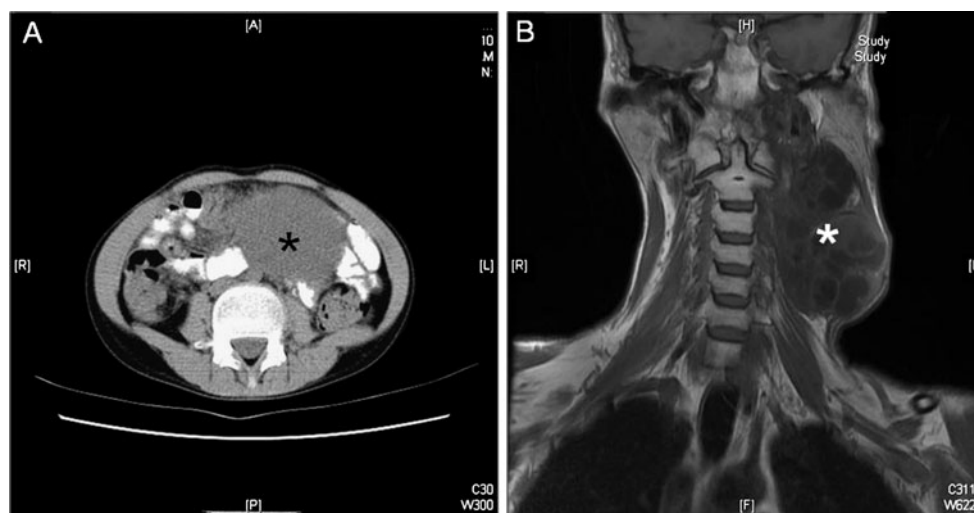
a Case 21. Computed Tomography (CT) scan of abdomen showing a large, hypodense soft tissue mass measuring $7.6 \times 11.2 \times 15$ cms, extending superiorly up to the level of the lower pole of the left kidney, with few calcific specks within. b Case 16. Magnetic resonance imaging (MRI) showing a large heterogeneous, lobulated, multicystic, septate mass measuring $9.9 \times 5.6 \times 10$ cm in the left parapharyngeal region
